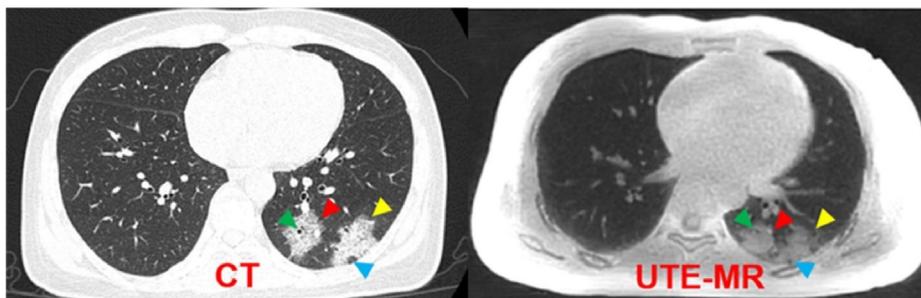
Representative CT and UTE-MR images of a female patient with coronavirus disease 2019. Reproduced with permission [23]. CT, computed tomography; UTE, ultrashort echo time; MR, magnetic resonance.
